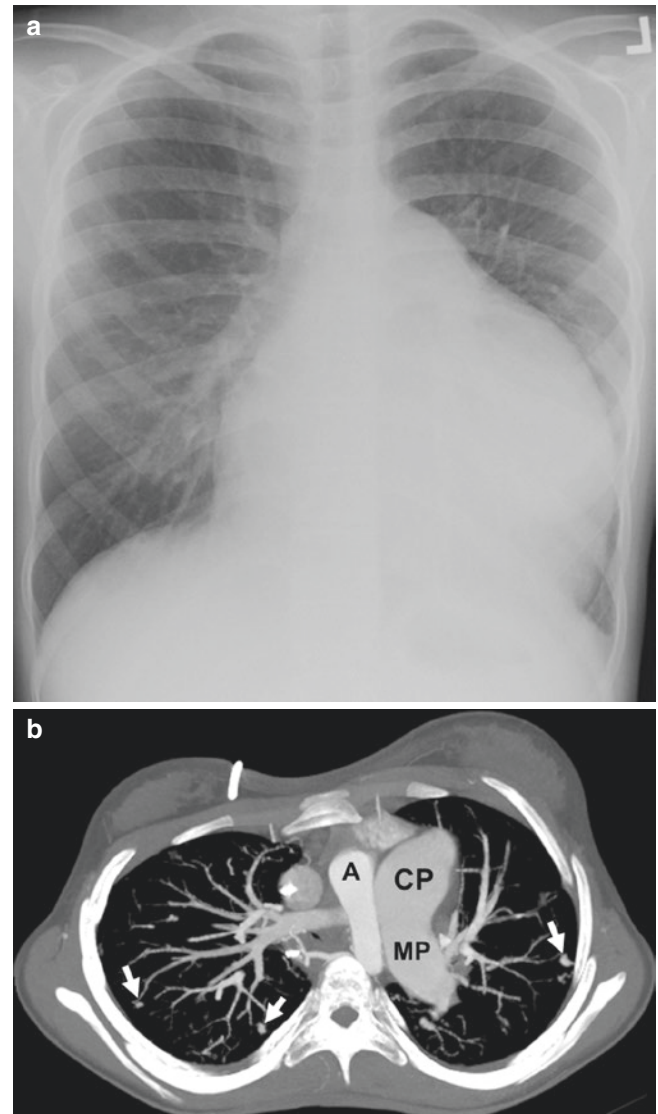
Sixteen-year-old girl with idiopathic pulmonary hypertension who initially presented with syncope and chest pain. (a) Frontal chest radiograph demonstrates a markedly enlarged heart and aorto-pulmonary window region. (b) Enhanced axial maximum intensity projection CT image shows markedly enlarged central pulmonary artery (CP) and main pulmonary artery (MP). Also noted is development of small, enlarged, and tortuous vessels (arrows) within the periphery of the lungs A aorta. (c) Coronal multiplanar CT image demonstrates a markedly enlarged right atrium (RA) and right ventricle (RV). (d) High-resolution axial lung window CT image demonstrates relatively well-defined centrilobular opacities (arrows) associated with areas of inhomogeneous ground-glass opacification
